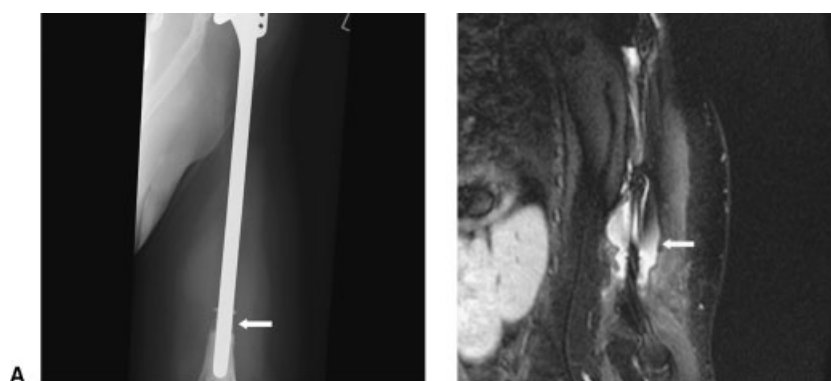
Conventional radiograph (A) of long-stem humeral hemiarthroplasty for reconstruction after proximal humeral resection for treatment of prior osteosarcoma demonstrates localized osseous resorption surrounding the distal humeral stem (arrow). Coronal STIR image (B) (TR/TE, 4200/15 milliseconds; TI 150 milliseconds) through this region demonstrates a localized fluid collection (arrow) with no evidence of recurrence. Aspiration revealed infection.
